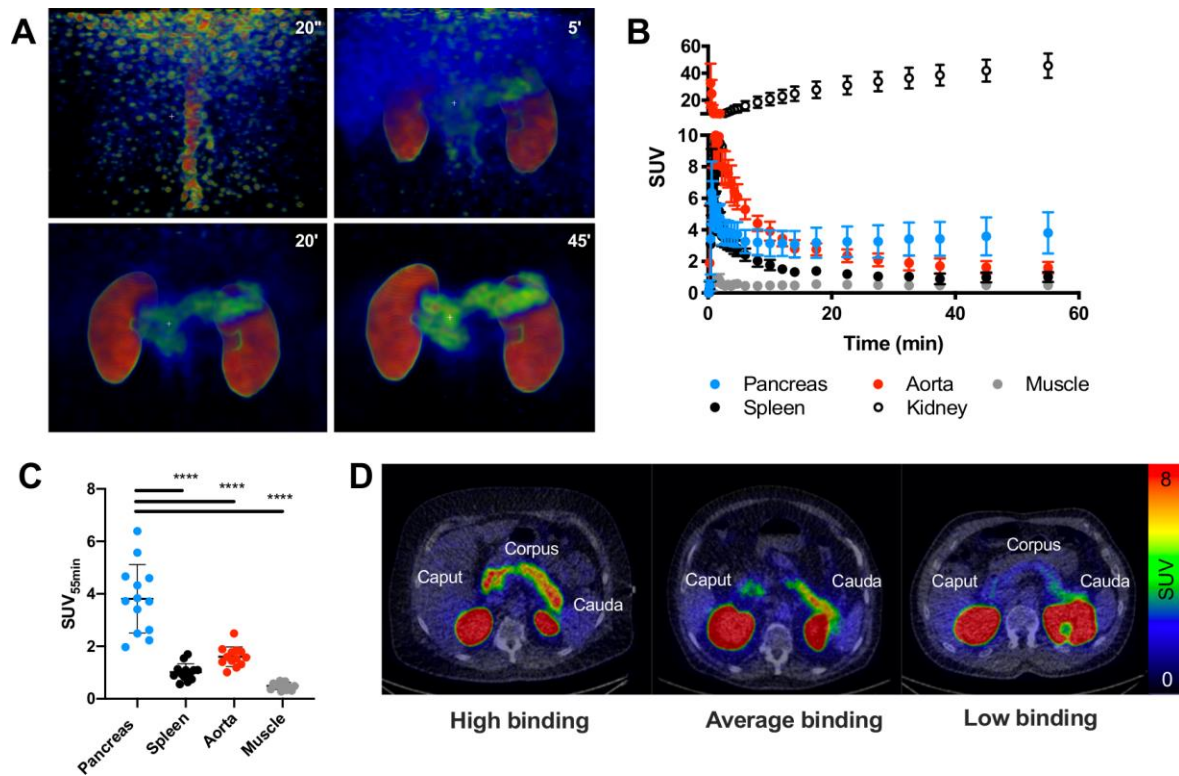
Abdominal biodistribution of ^{68}Ga -Exendin4 in humans with T2D. ^{68}Ga -Exendin4 was rapidly distributed followed by washout from most tissues except pancreas and kidneys (A and B, average of n=13 individuals). Representative maximum intensity projection (MIP) PET images are shown. There was strong variability in the pancreas binding, which was not reflected in other tissues (C). Representative transaxial PET/CT images demonstrating high (left panel), average (middle panel) or low (right panel) pancreas binding of ^{68}Ga -Exendin4 (D). The approximate surgical segment of the pancreas (caput=head, corpus=body, cauda=tail) is given as adjacent white text.
